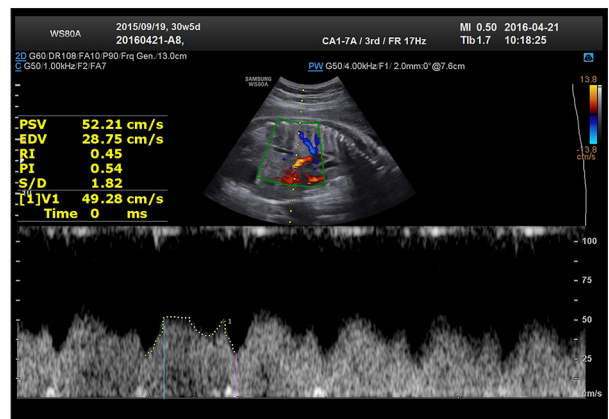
Ultrasound Doppler spectrum of fetal DV in the control group.
